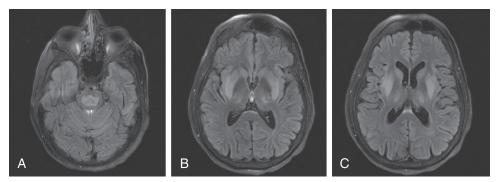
Central pontine and extrapontine myelinolysis—axial FLAIR images at the level of the pons (A) and basal ganglia (B and C) demonstrating classic central pontine pattern of involvement, as well as multiple symmetric sites of extrapontine involvement including the basal ganglia, thalami, and external capsules in a patient with history of alcohol abuse presenting with hyponatremia.
